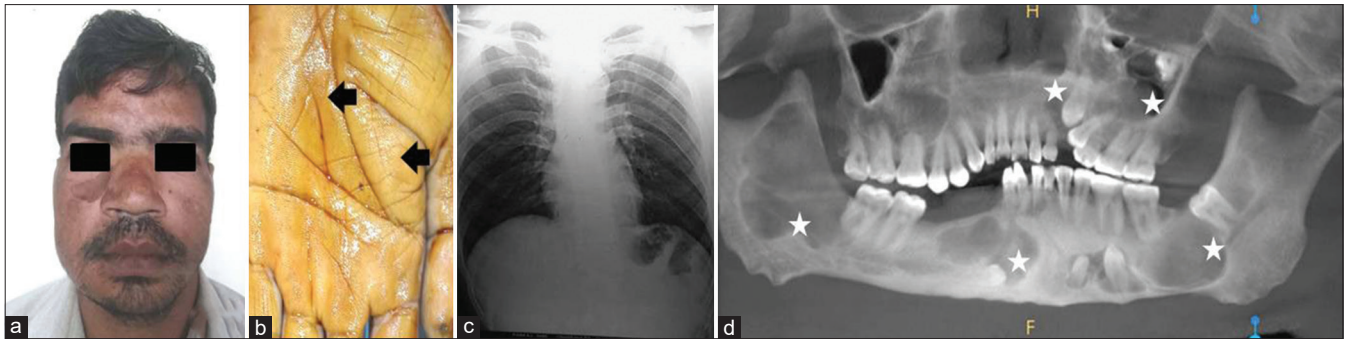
Case 3 is of a 33-year-old male showing (a) extraoral clinical photographs with hypertelorism, depressed nasal bridge, multiple nevus (b) plantar pits (c) no rib anomaly (d) orthopantomogram with multiple radiolucent lesions (white asterisk)
